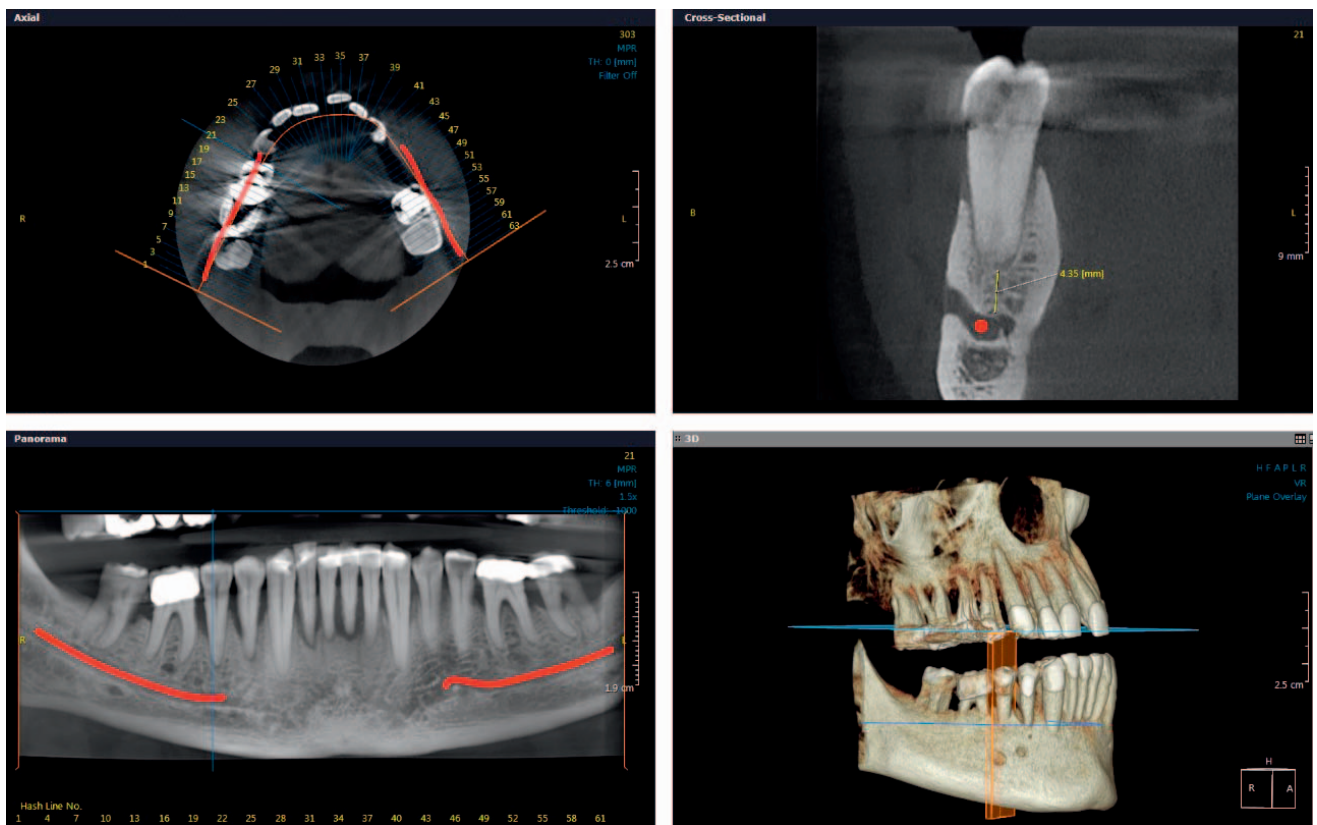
Measurement of root-to-alveolar canal in second mandibular premolar. Three dimensions, axial, panoramic, and cross-sectional cone beam computed tomography reconstructions.
